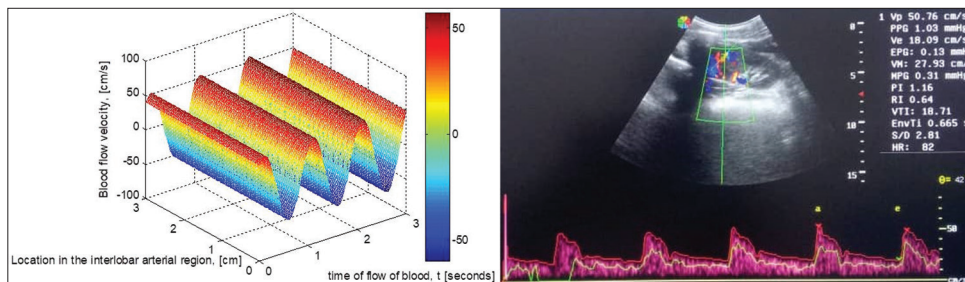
The three-dimensional variation in the flow velocity across the interlobar arterial cross-sectional area and the Doppler indices of the left interlobar artery. The waveform clearly outlines the pulsatility nature of the renal interlobar artery.<sup>[1,50,51,57]</sup>
